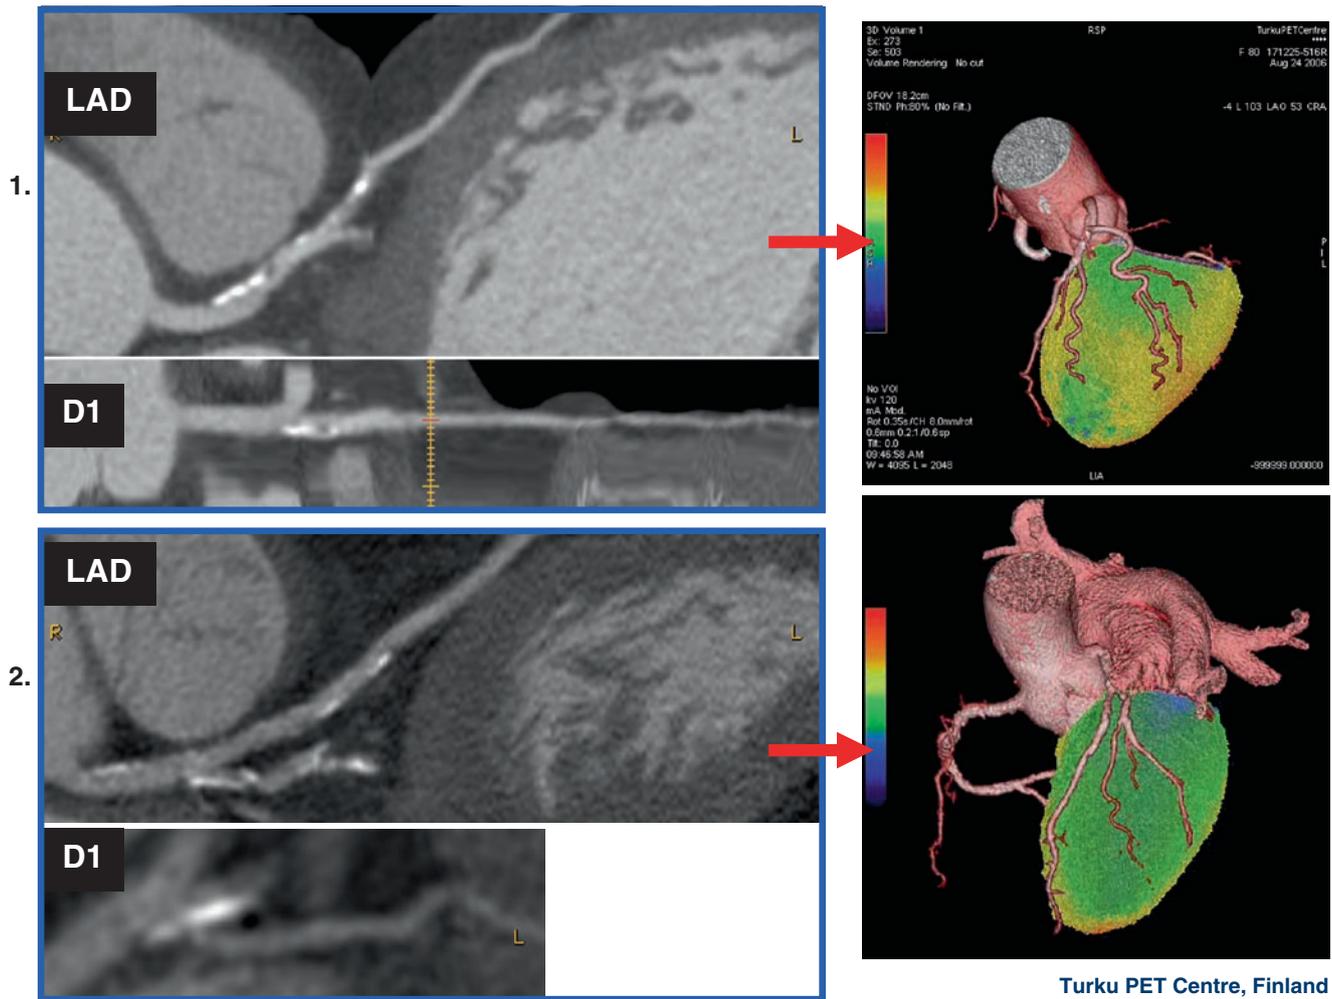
Examples of two clinically similar symptomatic patients who had also similar findings in LAD and the first diagonal branch (D1) in CT angiography (left panels). The patient 1 (upper row) showed in hybrid
